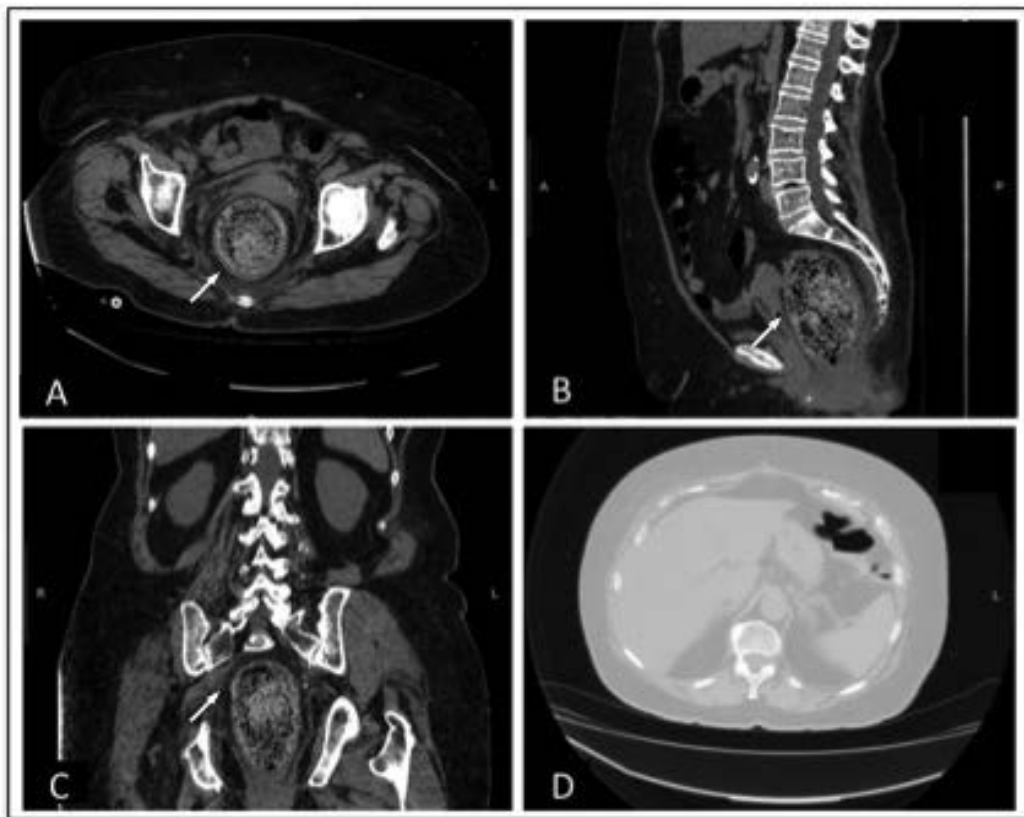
Abdominal computed tomography examination. Un-enhanced CT in axial plane (A) and multiplanar reconstructions (B) sagittal, (C) coronal, shows a large mass-like lesion in the rectal vault (white arrow), composed of tightly packed densities having variable HU values (60-120) with interposed air. There were no signs of complications, such as fluid in the peritoneal cavity or small air bubbles (D), axial image passing through upper abdominal quadrants and viewed at lung window settings.
